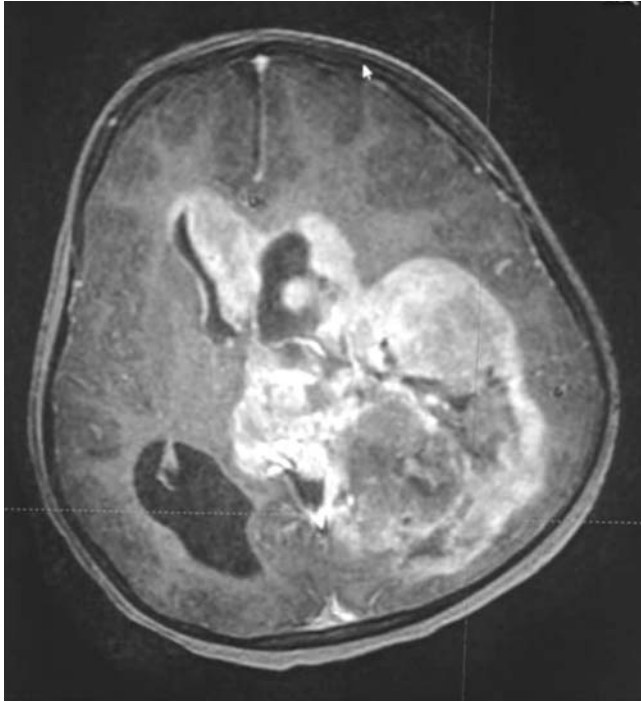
A sagittal section of MRI brain T1 post-contrast, showing a large intra-axial lesion in the frontal, parietal, temporal and occipital lobes, with heterogenous peripheral enhancement and central necrosis. There is meningeal enhancement as well at the skull-base, signifying leptomeningeal spread of the disease. Biopsy of this lesion was reported as Glioblastoma grade IV.
